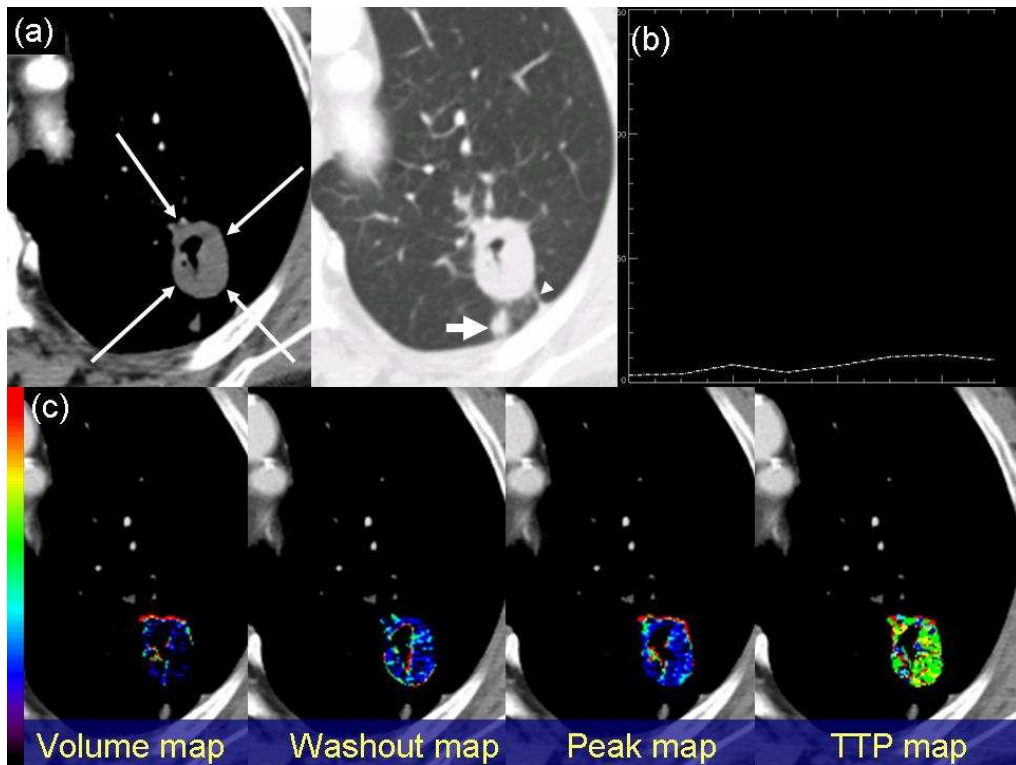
Chest CT and parametric perfusion maps in a 63-year-old woman with tuberculosis in the left upper lobe apicoposterior segment.
